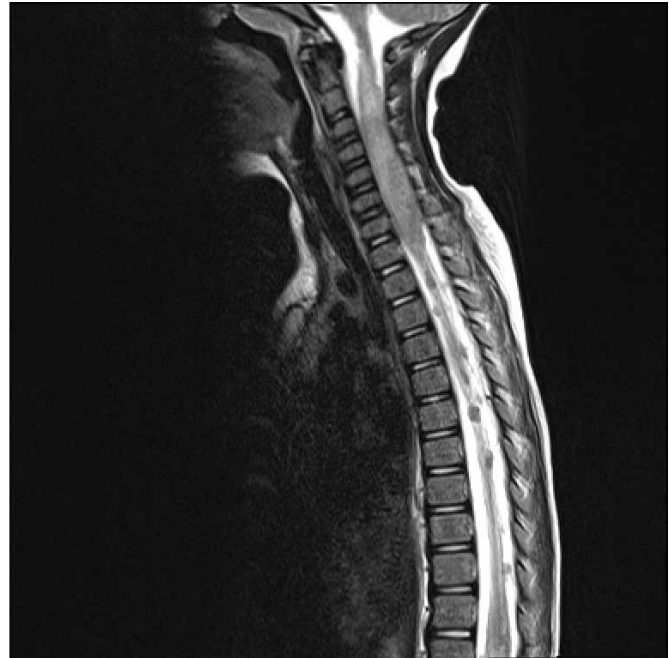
Magnetic resonance imaging (MRI) revealed an intradural extra-intramedullary lesion in the cervical spinal canal from C1 to T1, heterogenous on T2-weighted image (T2WI) and associated with multiple intradural extramedullary drop metastases.
